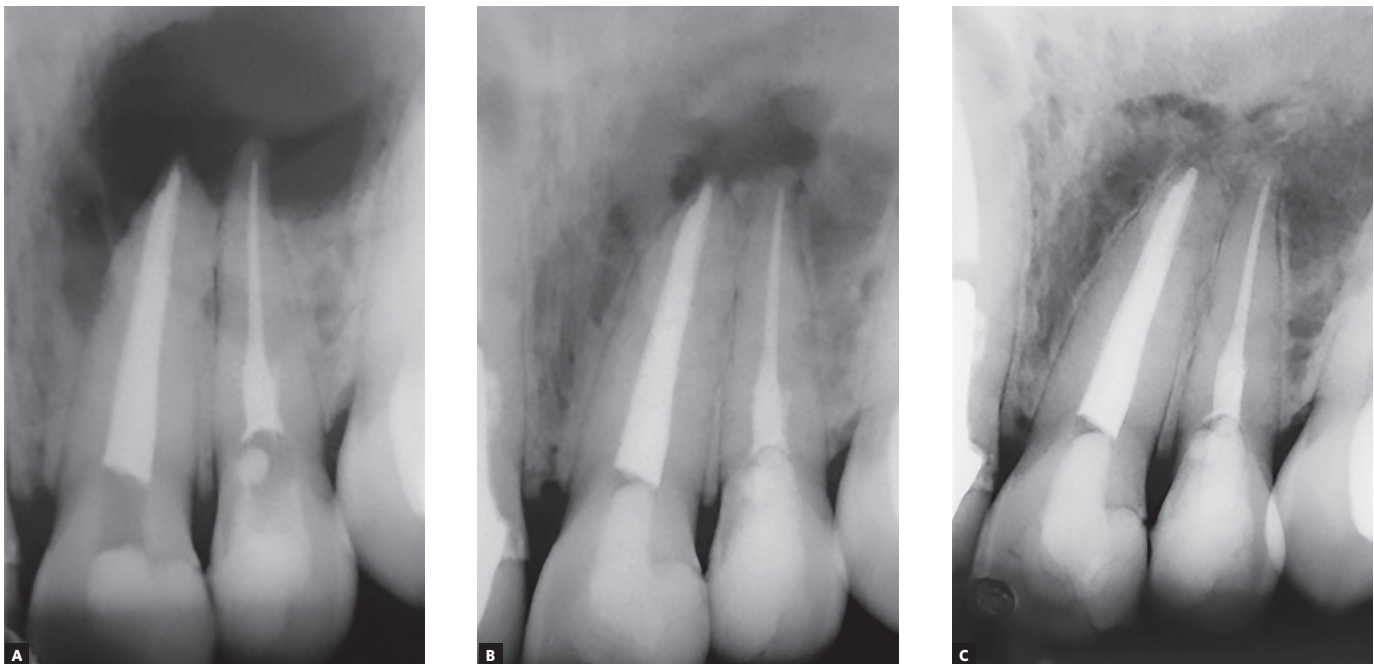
A) Radiographic appearance after filling, sealing of the perforation, and surgical removal of the lesion. B) Follow-up exam after eight months C) Follow-up exam after five years and five months.
